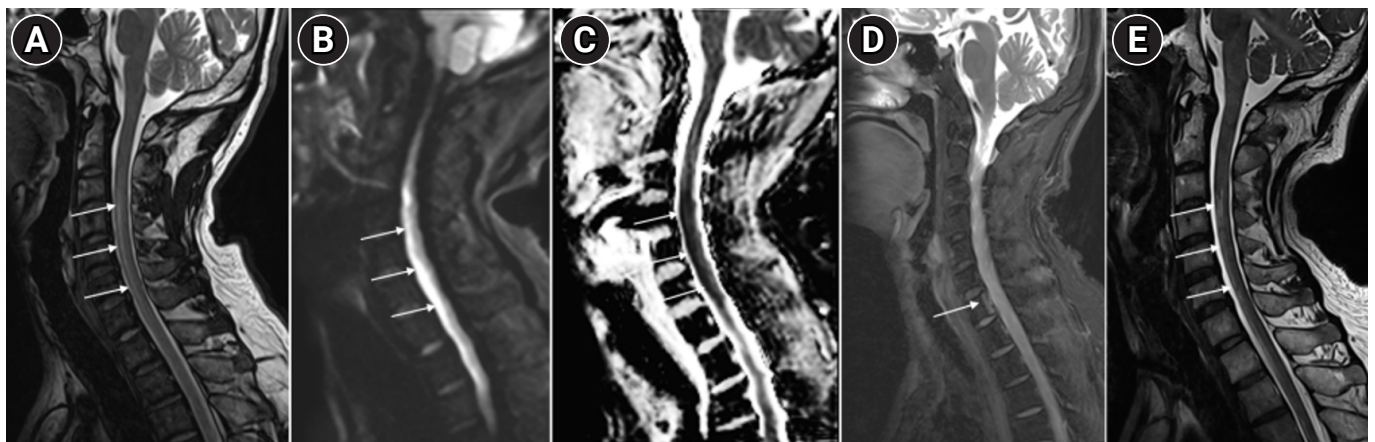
Magnetic resonance imaging findings. (A) T2-weighted image reveals high signal intensity and swelling (arrows) in the anterior aspect of the spinal cord from C3 to C7. (B) The lesion site exhibits high signal intensity (arrows) on diffusion-weighted imaging (b 800). (C) Apparent diffusion coefficient image shows low signal intensity (arrows). (D) Fat-suppressed image demonstrates high signal intensity in the posterior one-third of the C7 vertebral body (arrow), indicative of bone infarction on day 12. (E) Three months after symptom onset, the cervical cord maintains high signal intensity (arrows) on T2-weighted imaging.
